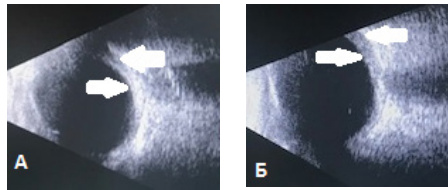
Ultrasonograms of the right (A) and left eye (B) eyeball of patient P., 71 g (white arrows indicate the thickened choroid of the posterior pole of the eye)
